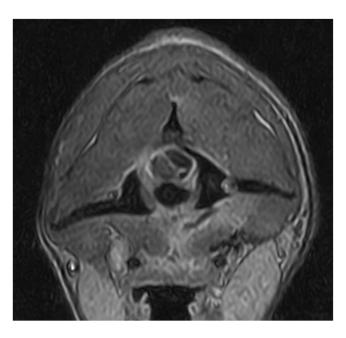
MRI of the cervical spine: T2W sagittal (a) and transverse (b) image. Dorsolateral, left-sided focal, well-demarcated extradural T2W hypointense linear structure within the vertebral canal at the level from C1 to mid-C2 cervical vertebral body. Deviation of the spinal cord to the right and loss of surrounding cerebrospinal fluid (CSF)-fat signal; spinal cord oedema with intramedullary T2W-hyperintensive signal caudally to the compressive lesion extending to the end of the vertebral body of C2
